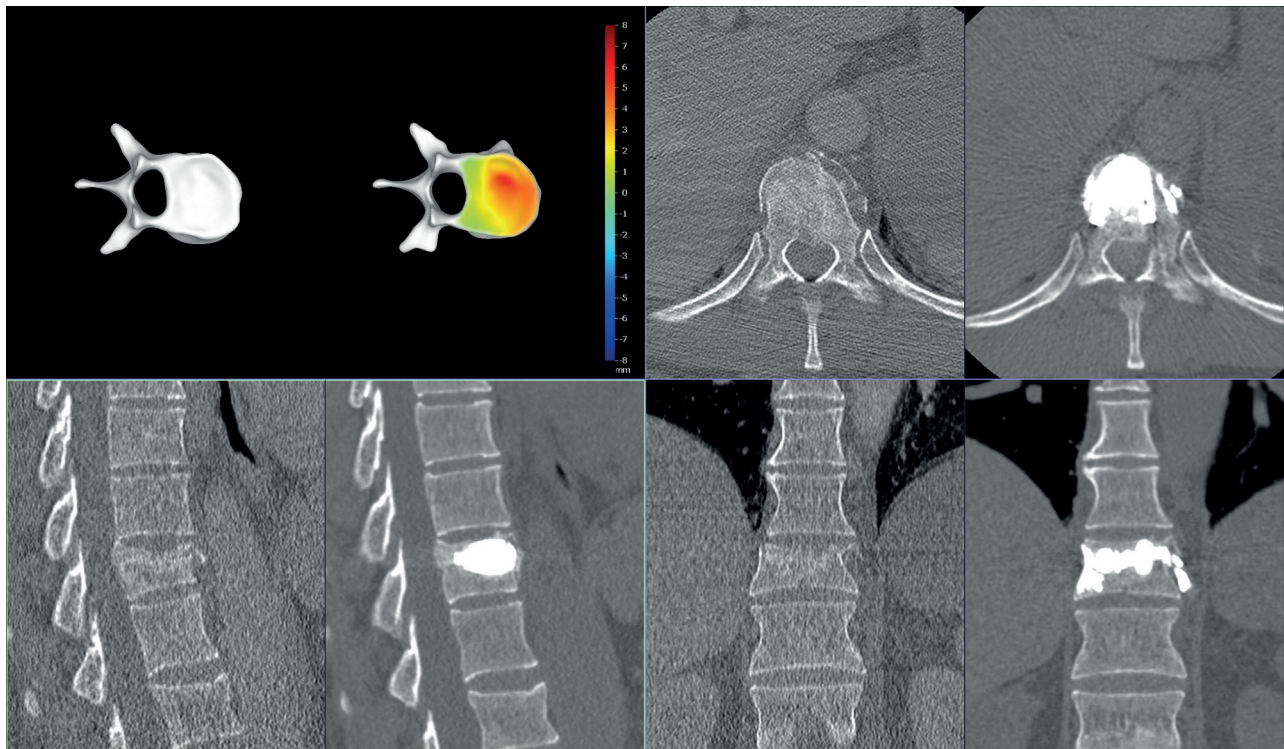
Preoperative and Postoperative CT scans of T10 vertebra evidencing anterior height restoration after the SpineJack® procedure was performed. A 3D mapping showing the amount of restoration of the superior endplate
